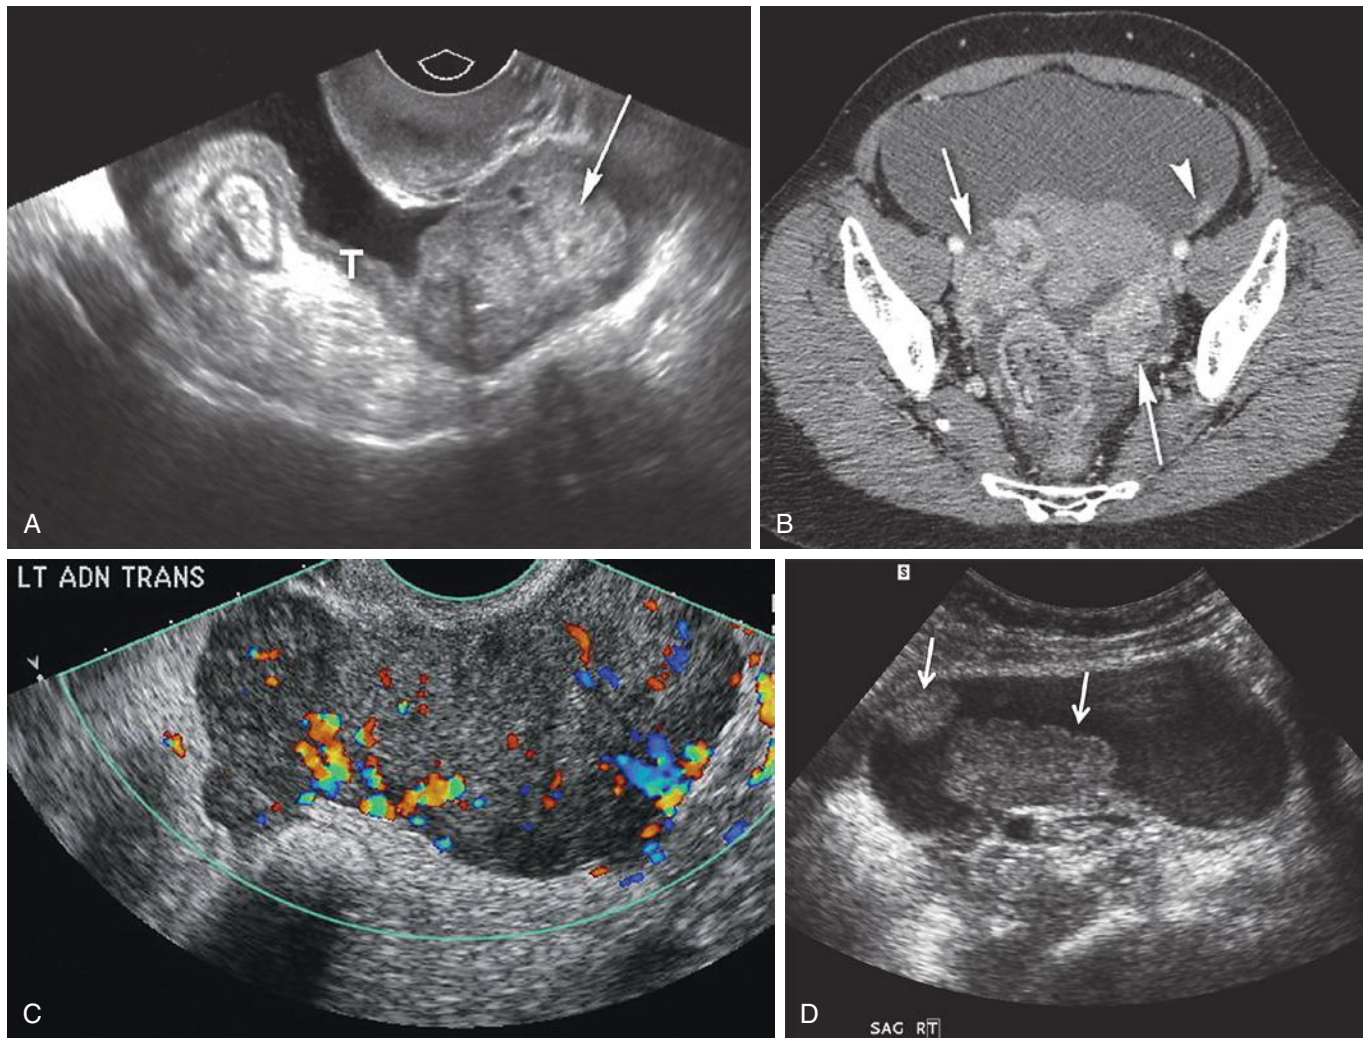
Fallopian tube carcinoma. A, Anechoic ascites partially surrounds the hypoechoic left fallopian tube (T), which has an abnormally thick, slightly heterogeneous solid mass-like appearance at the distal end (arrow). B, Corresponding axial contrast-enhanced computed tomographic scan demonstrates bilateral abnormal fallopian tubes (arrows), which are thickened, nodular, and enhancing. There is a large amount of surrounding ascites. Note enhancing peritoneal implant (arrowhead). C, Color Doppler image demonstrating a solid, vascular left adnexal tubular structure in another patient with primary fallopian tube cancer. D, A 43-year-old woman with fallopian tube cancer presented with vaginal bleeding. Transvaginal sonographic image demonstrates right hydrosalpinx containing two solid mural nodules (arrows) highly suggestive of malignancy rather than chronic inflammation as the wall of the fallopian tube is otherwise thin and smooth. (C courtesy of Dr. Douglas Brown, Department of Radiology, Mayo Clinic, Rochester, MN; D courtesy of Dr. Anna Lev-Toaff, Hospital of the University of Pennsylvania, Philadelphia, PA.)
